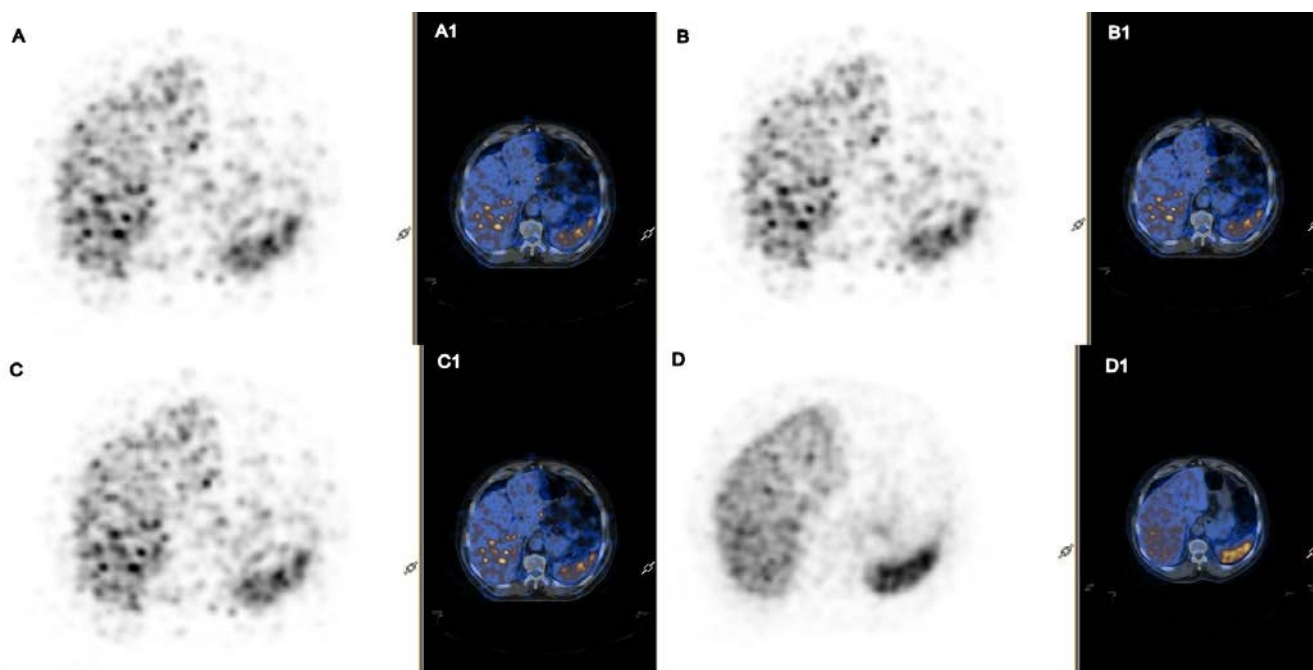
Transverse plane of patient imaging (whole body CTAC) for 30 s in PET (A) and PET/CT (A1), 45 s in PET (B) and PET/CT (B1), 60 s in PET (C) and PET/CT (C1) and 80 s in PET (D) and PET/CT (D1) acquisitions.
